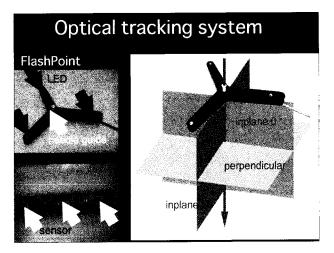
Optical tracking system. FlashPoint has an LED at the end of the three arms (left upper, *black arrows*). A biopsy needle is introduced through the center hole (left upper, *white arrow*). Sensors which receive signal from the LEDs are installed in the ceiling of the magnet housing (left lower, *arrows*). MR images are obtainable on three planes; axial, coronal and sagittal, or on any three planes perpendicular each other (right)
